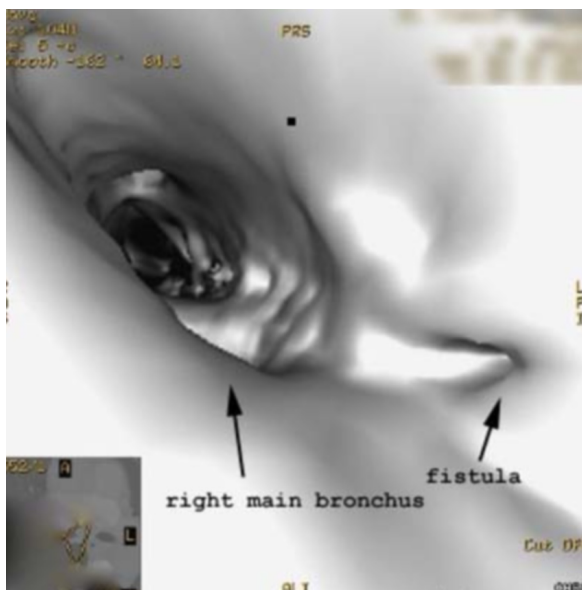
Endoluminal three dimensional CT image from the vantage point of the trachea, peering down towards the right main bronchus, demonstrates the orifice of the bronchoesophageal fistula.
